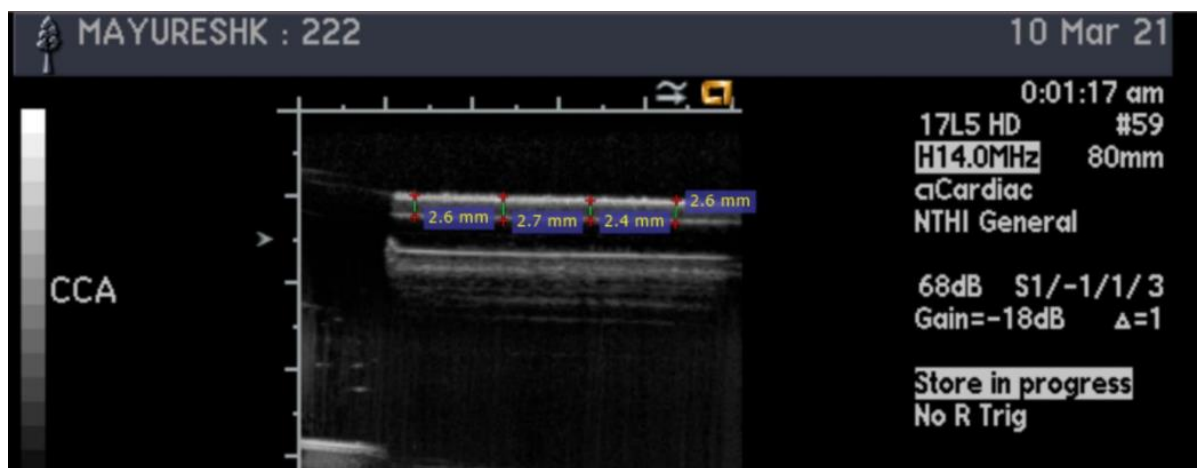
Ultrasound measurement of brachial artery thickness
